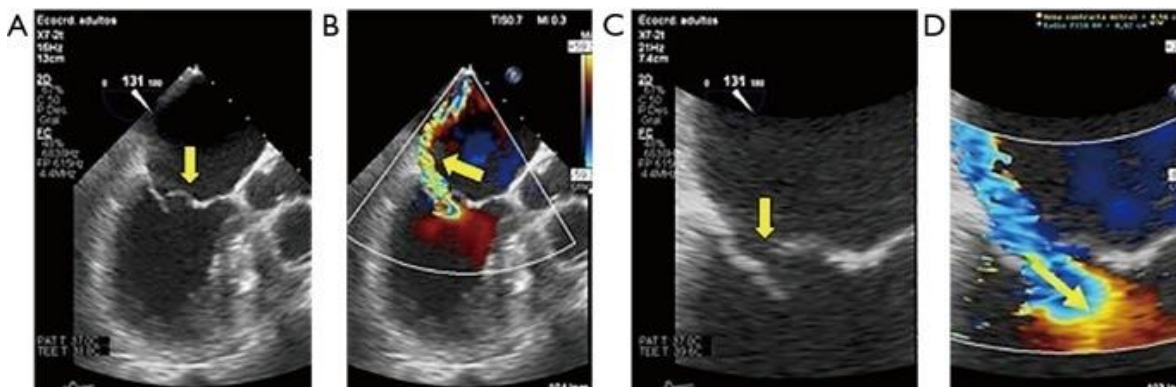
Transesophageal echocardiography, or TOE enables a more precise quantifying tenting area, traction, mitral ring, and reduction in the apposition surface. (A) Reduction in the apposition surface (yellow arrow); (B) Coanda impact in IMR (yellow arrow); (C) Transesophageal echocardiography zoom-mode of the mitral valve with a reduction in mitral valve apposition surface (yellow arrow); (D) proximal isovelocity surface area and mesosystolic area (yellow arrow) ⁽²¹⁾.
